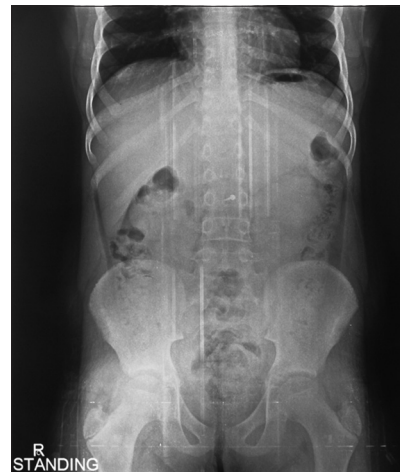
Anteroposterior abdominal radiograph showing the presence of the anchorage screw in the abdominal cavity
